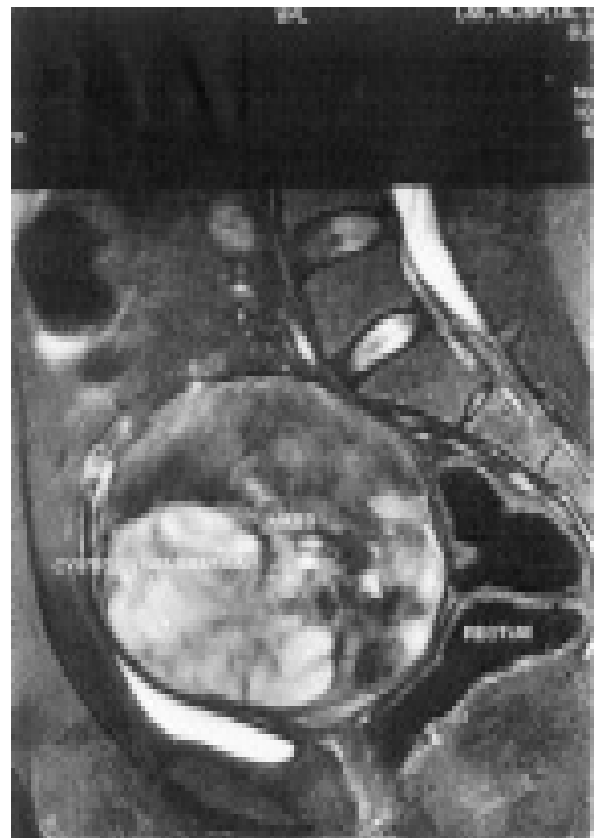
MRI showing mass in the posterior lip of the cervix
